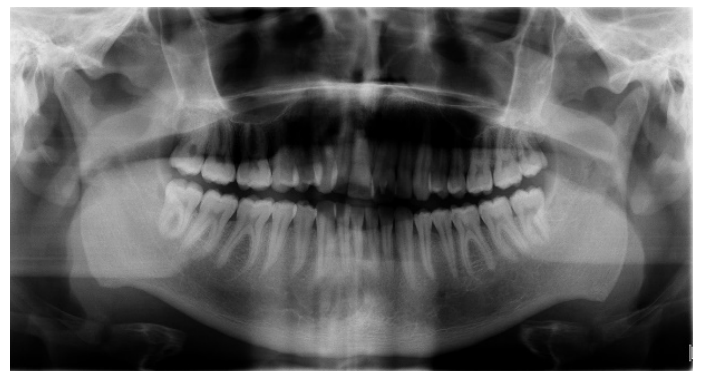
Panoramic radiography of the teeth.
